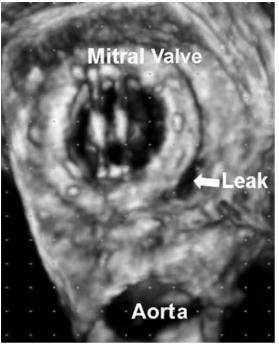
Three-dimensional transesophageal echocardiography showing the mitral paravalvular leak on the anterolateral portion of the mitral valve annulus.
